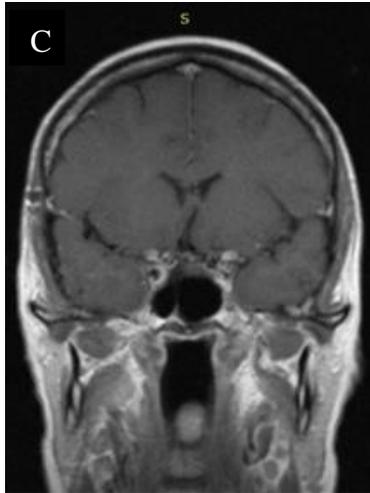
Postoperative axial (A), sagittal (B) and coronal (C) images of T1 with contrast MRI scan confirming the total resection of the tumour
